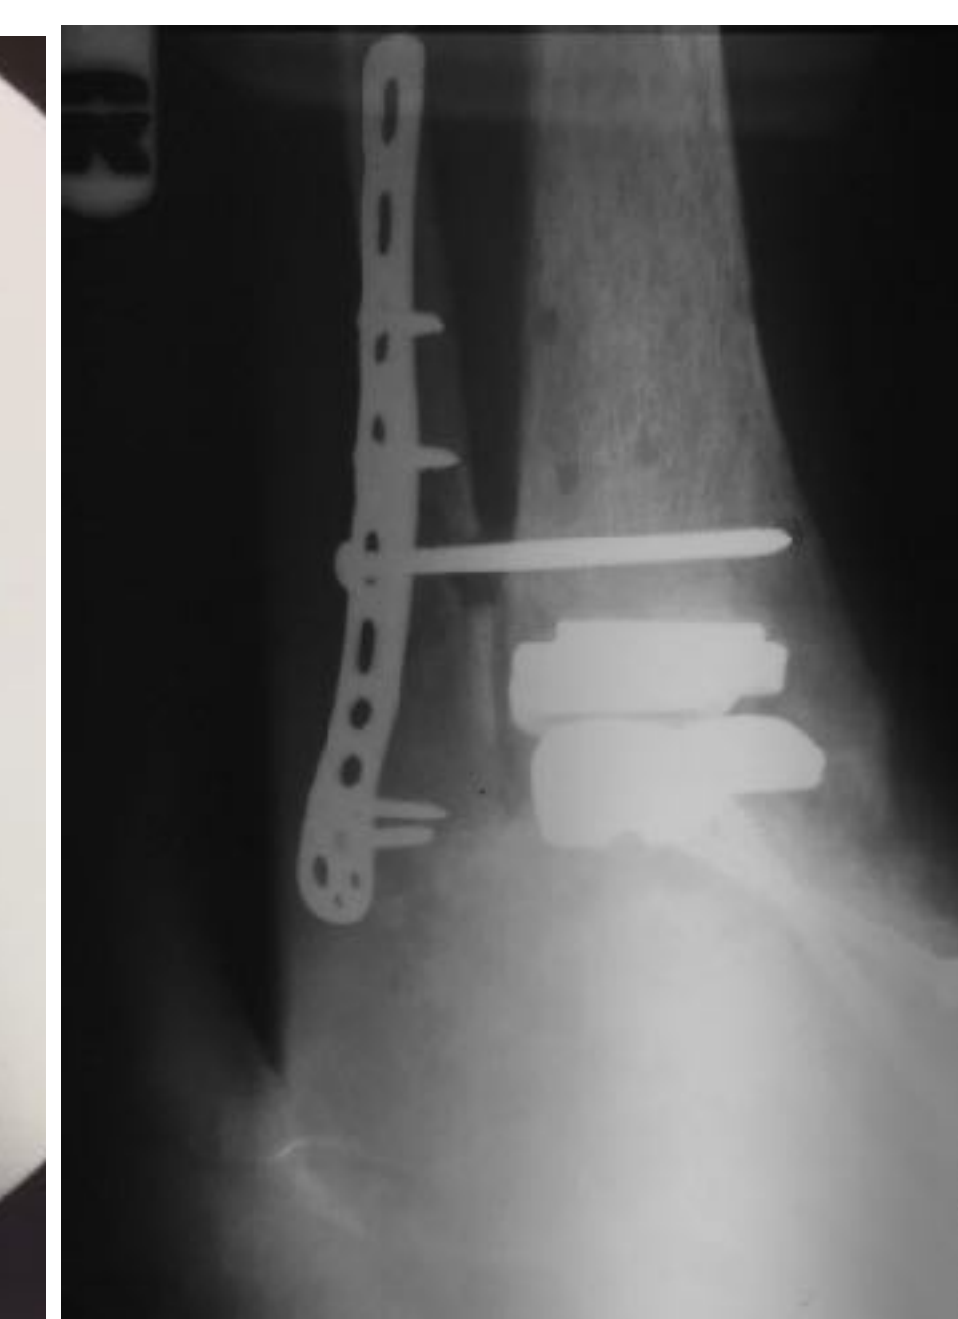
Post-op AP weight bearing X-ray of the ankle following repair of the medial deltoid ligament implant in good anatomic alignment
